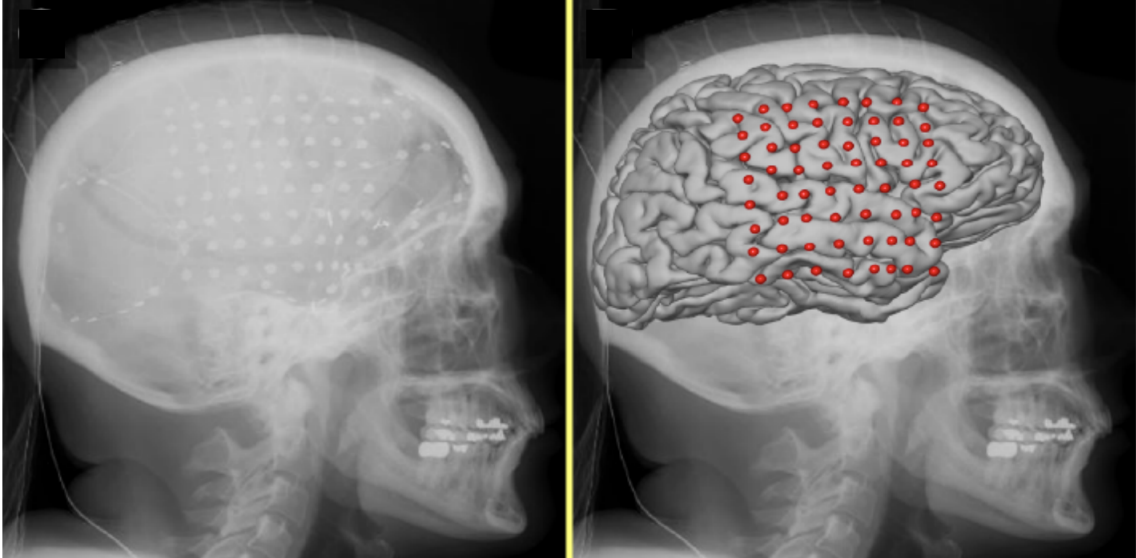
CT scan and co-registration of grid
